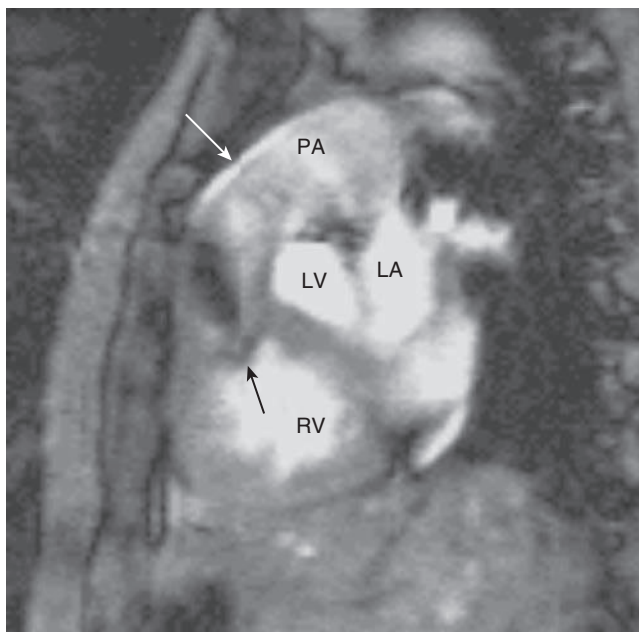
This gradient echo cine magnetic resonance image (TE = 14 ms) in an oblique parasagittal plane aligned with the right ventricular outflow tract (RVOT), is from an adult with a double-chambered right ventricle (DCRV). Taken during systole, it demonstrates the obstructing muscle bundles (black arrow) dividing the hypertrophied proximal RV and the thin-walled infundibular region. High-velocity flow distal to the obstructing muscle bundles is represented by the dark jet. The white arrow indicates the level of the pulmonary valve. LA, Left atrium; LV, left ventricular outflow tract; PA, pulmonary artery; RV, right ventricle. (Courtesy Philip Kilner, Royal Brompton Hospital, London, UK.)
